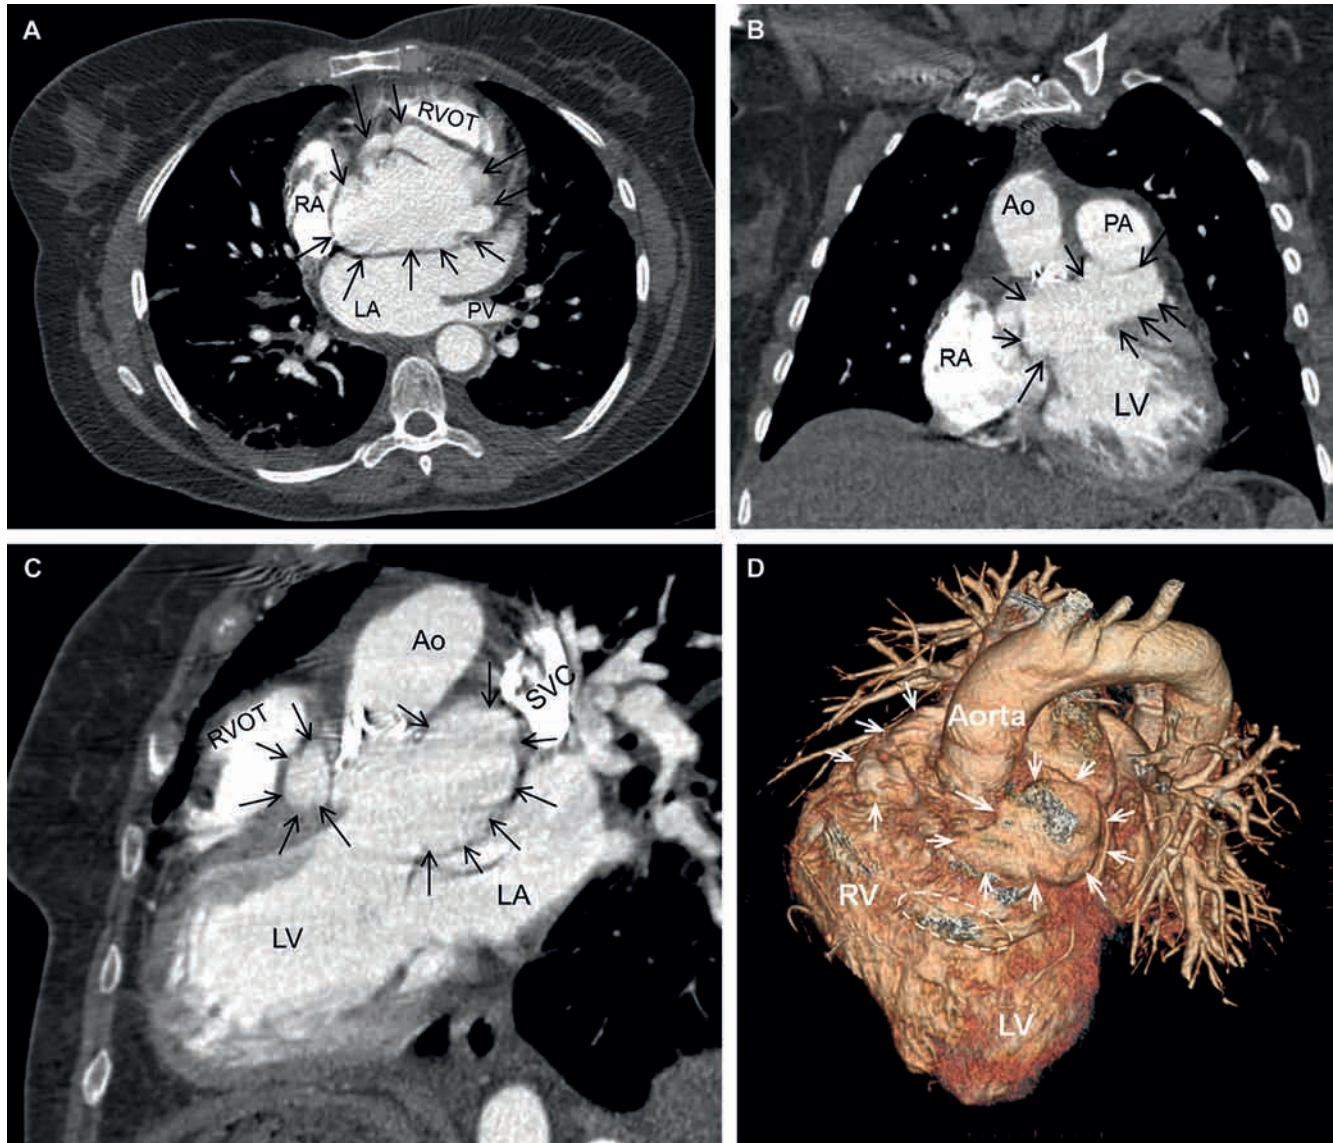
Contrast enhancement axial (*Panel A*), coronal (*Panel B*), and oblique (*Panel C*) computerized tomography (CT)-scan showing the dilation at the aortic root (black arrows). Note: bilobed configuration, best seen in oblique and coronal (*Panel B* and *Panel C*) planes. Contrast-enhanced CT demonstrates all cardiac chambers and arrows outline the pseudoaneurysm. *Panel D*. 3D Volume reduction preoperative image delineates the outpouching of the suspected pseudoaneurysm (arrows) on both sides of the aorta. Dashed oval: Right ventricular outflow tract (selectively removed to visualize the out pouching). RV = right ventricle; LV = left ventricle; RA = right atrium; PA = pulmonary artery; Ao = aorta; RVOT = right ventricular outflow tract; SVC = superior vena cava.
